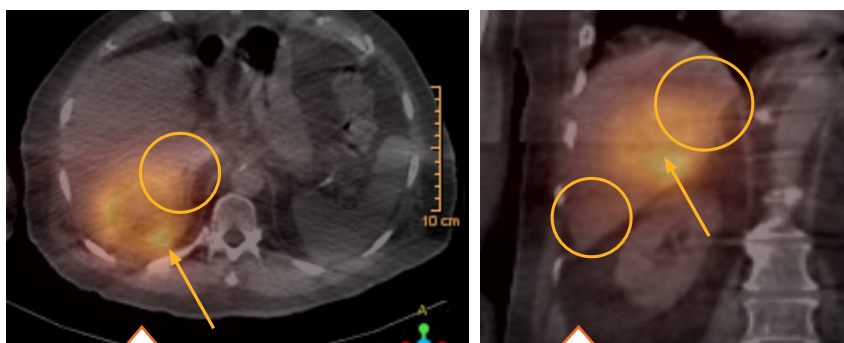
Post-Y90 SPECT-CT imaging in axial (left) and coronal (right) projections. Glass Y90 particles were delivered using TriNav via the posterior division of the right hepatic artery. SPECT-CT demonstrates preferential delivery to the tumor (yellow arrows), and less non-target activity in surrounding hepatic parenchyma (yellow circles) compared to MAA delivery using standard microcatheter.
